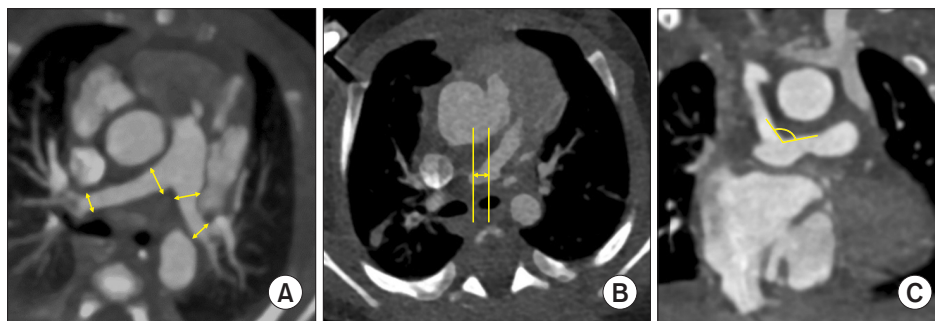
(A) The right pulmonary artery (RPA) and left pulmonary artery (LPA) diameters just before the first lobar bifurcation were measured using an axial computed tomography (CT) view. The maximum diameters of the RPA and LPA were also measured. (B) The distance between the perpendicular planes at the main pulmonary artery (MPA) bifurcation and the center of the shunt was measured using an axial CT view. (C) The angle between the modified Blalock-Taussig shunt and MPA was measured using a coronal CT view. The lines are tangents of each structure.
